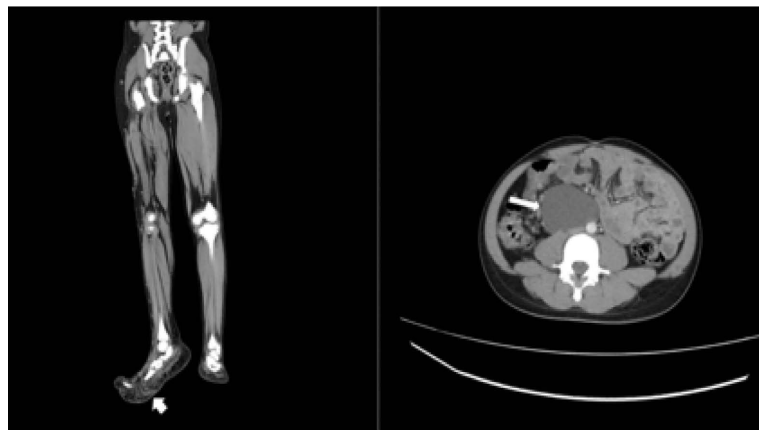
Coronal reformatted computed tomography of the lower limbs and axial image of the abdomen demonstrated fatty overgrowth of the subcutaneous tissues of the right foot (short arrow). A well circumscribed cystic retroperitoneal lesion is seen in the lower abdominal region (long arrow).
